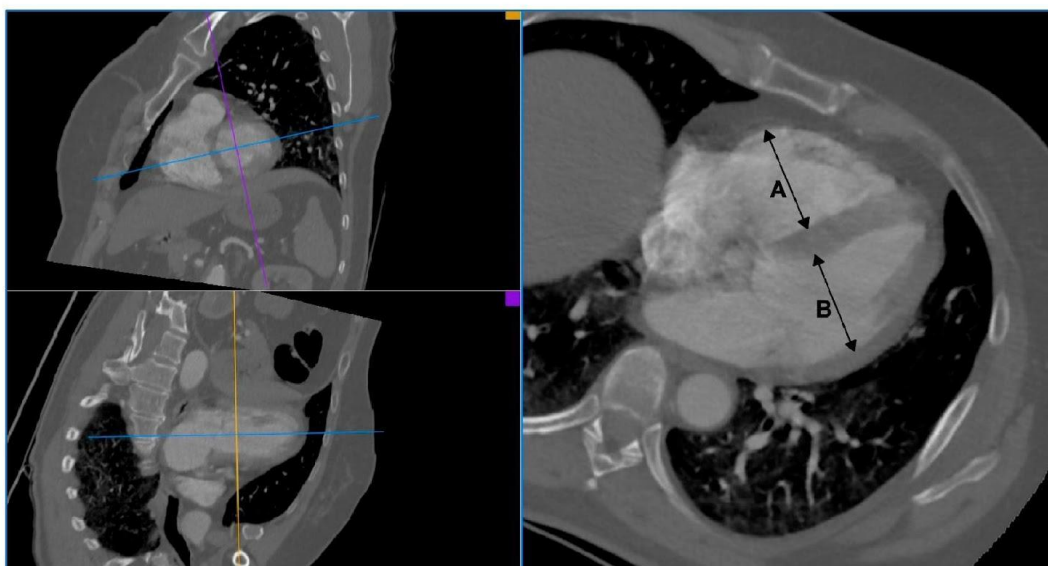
An example of RV/LV ratio measurement in CTA of pulmonary arteries. A: right ventricle diameter, B: left ventricle diameter.
